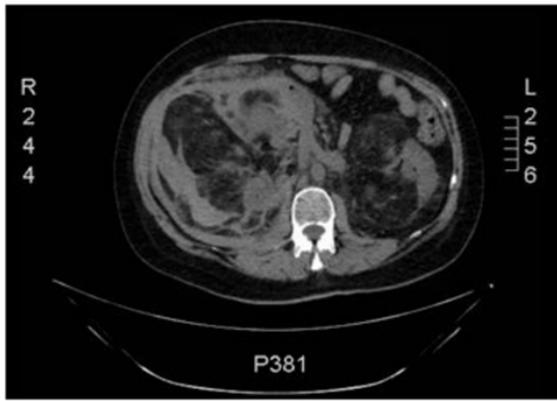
Non-contrast enhanced CT of the abdomen with Bilateral fat-rich Angiomyolipomas of the kidney and extensive right peri-renal fluid consistent with hemorrhage
